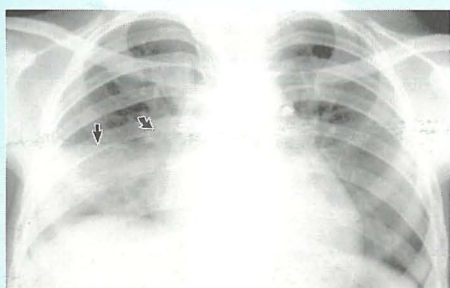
Chest X-ray shows right middle lobe infiltrate (straight arrow) and right hilar lymphadenopathy (curved arrow).
